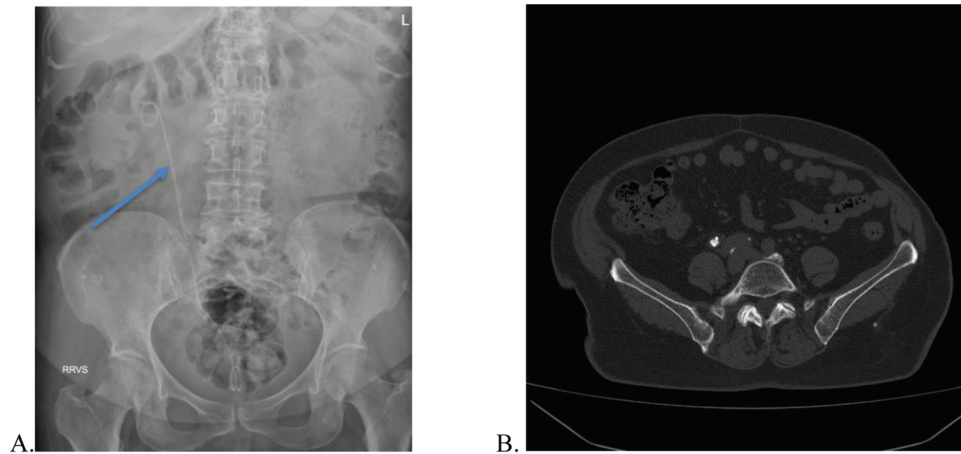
Postoperative radiograph and CT (axial image taken at the level of the inferior abdomen), showing successful stone fragmentation and placement of the double J stent.
